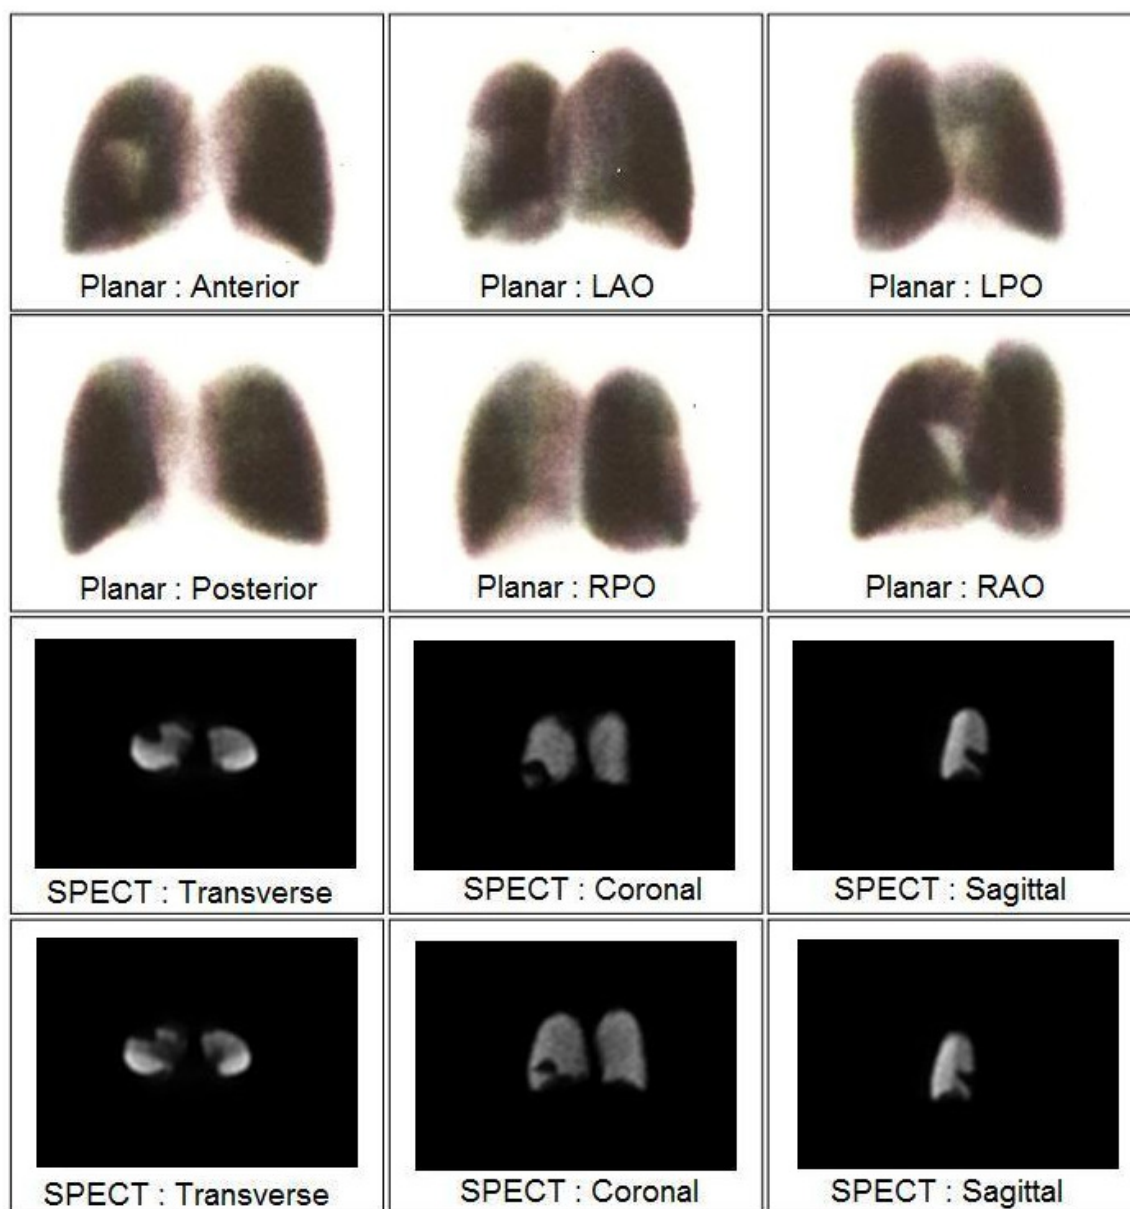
Planar and SPECT images of perfusion defect within the lateral segment of the right middle lobe.
